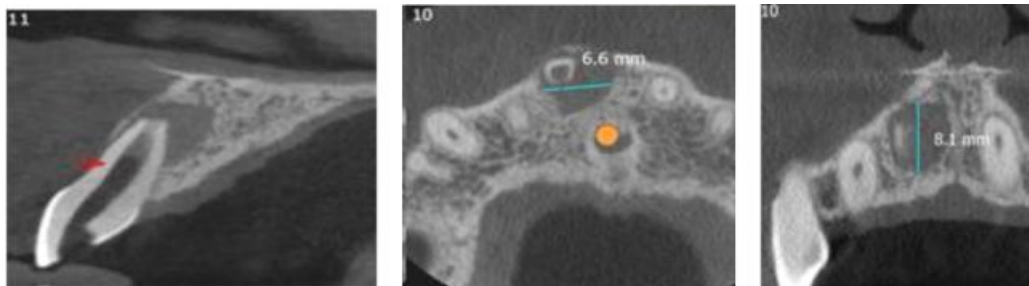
CT scan images of lesion at: (a) sagittal (b) axial and (c) coronal sections
